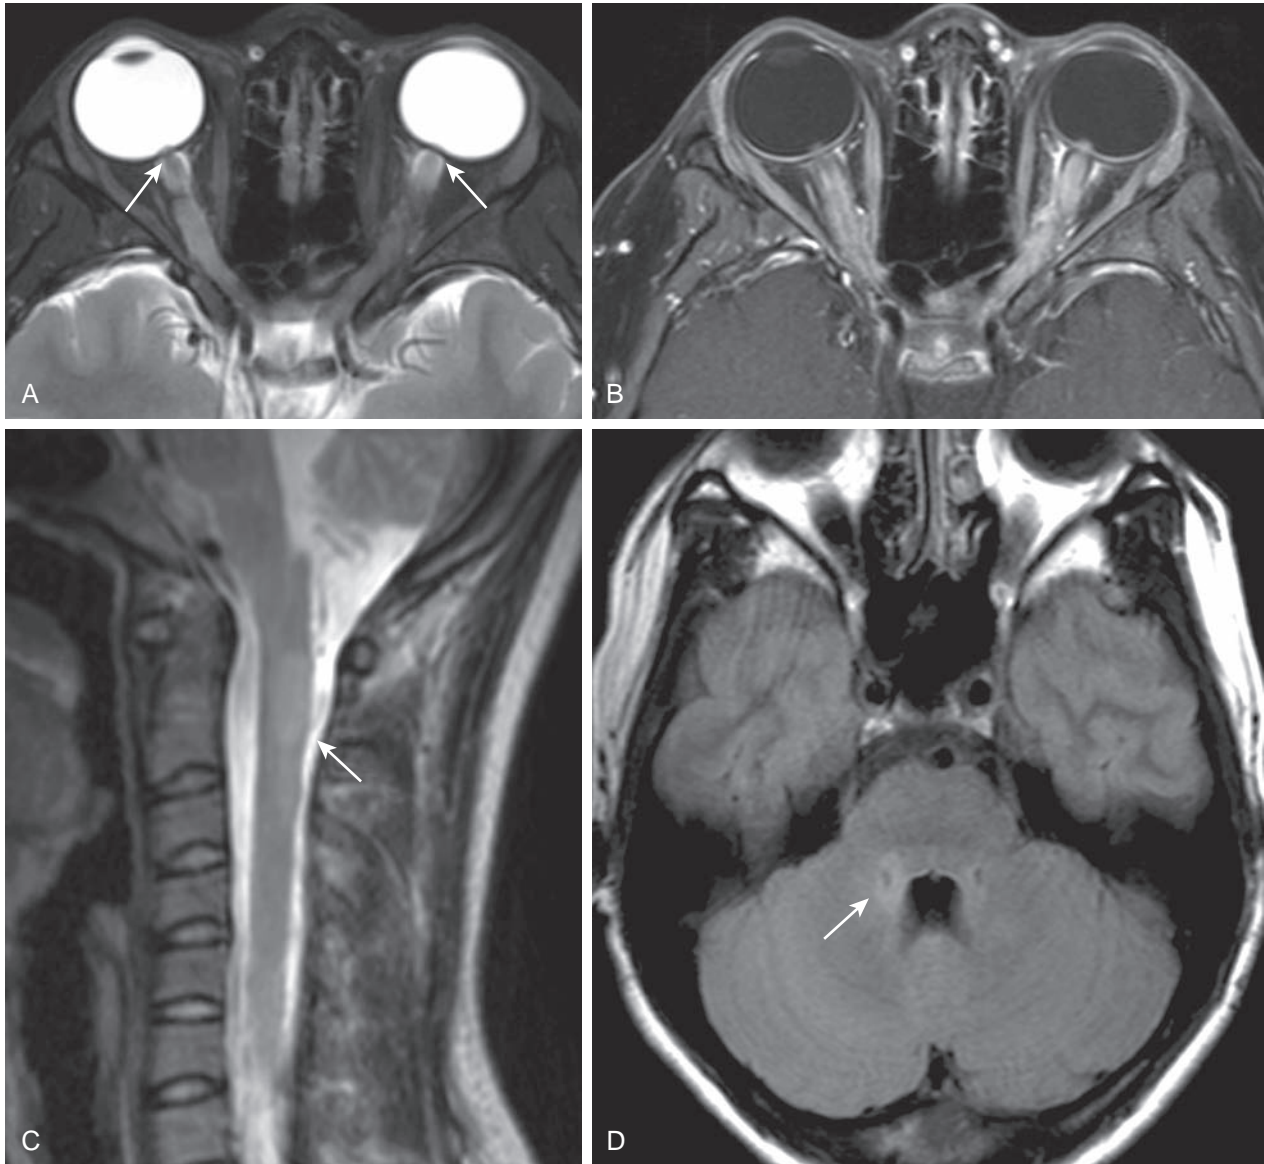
Optic neuritis. (A) Axial T2-weighted and (B) T1-weighted fat-saturated postcontrast MR images of the orbits demonstrating abnormal T2 hyperintensity and enhancement of the bilateral optic nerves with papilledema (arrows). (C) Sagittal T2-weighted MR image of the cervical spine demonstrates a characteristic central long segment cord lesion in a patient with neuromyelitis optica (NMO) (arrow). (D) Axial T2-weighted fluid attenuated inversion recovery MR image in the same patient with NMO demonstrating subtle hyperintensity adjacent to the fourth ventricle in regions of high aquaporin 4 concentration (arrow).
